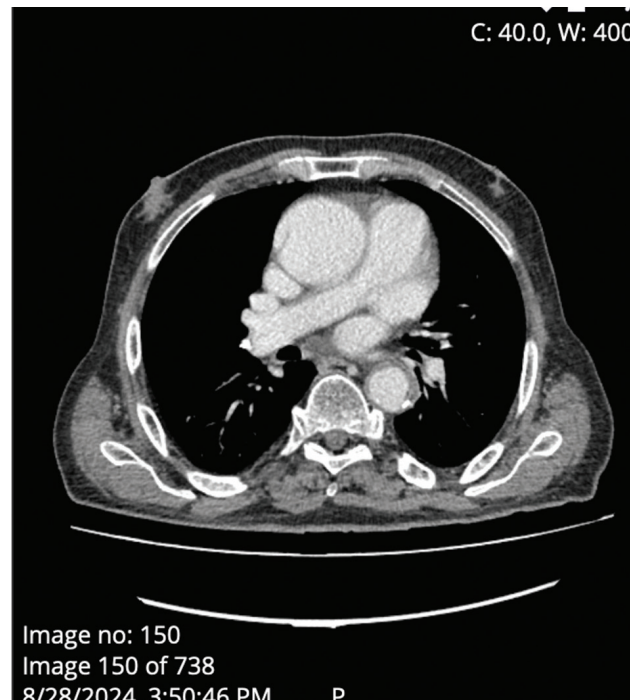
Ascending aorta dissection on computed tomography angiography of the aorta.
